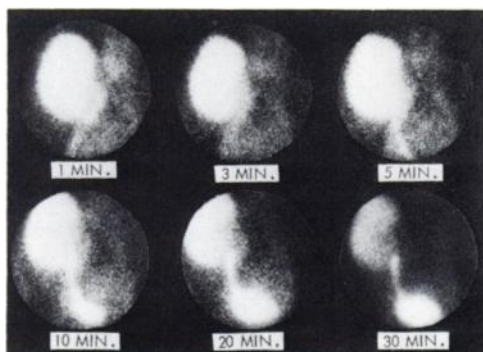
Normal renal transplant scintigraphic study using $^{99m}\text{Tc-Sn-DTPA}$.
